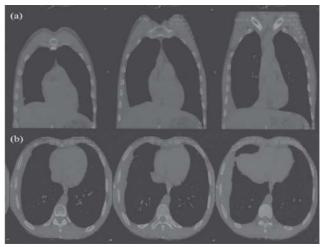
Contrast enhanced computed tomography of thorax (A) (coronal view) showing massive right-sided pleural effusion and (B) (axial view) showing pleural thickening.
